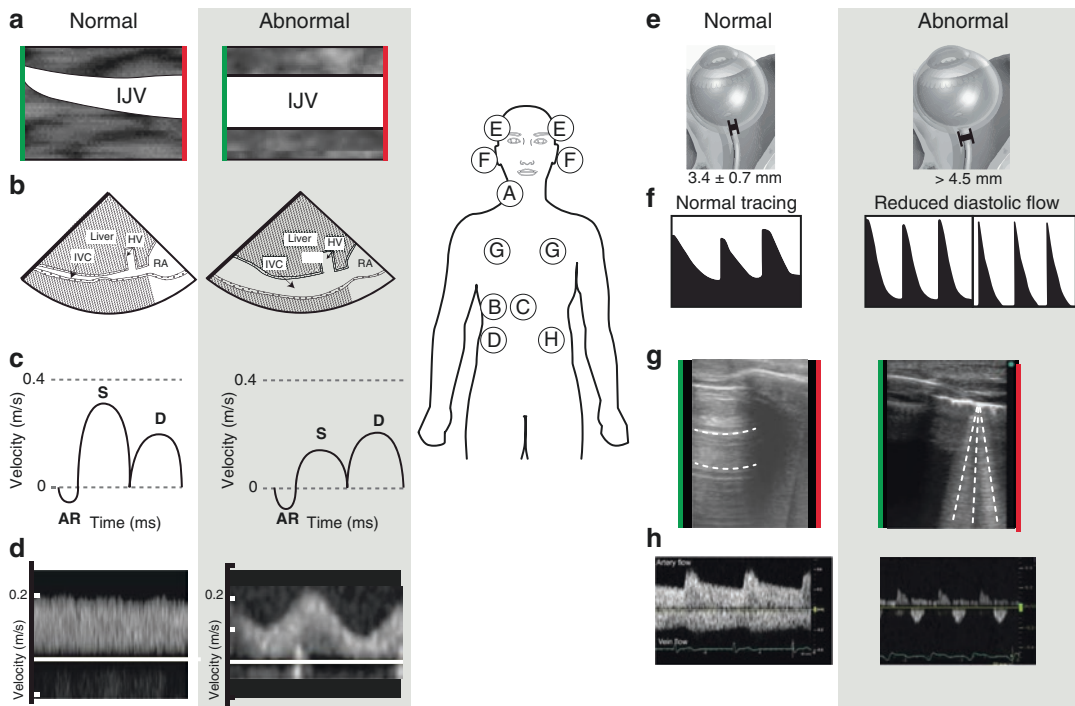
Extra-cardiac ultrasound signs of fluid overload. (a) Internal jugular vein (IJV), (b) Inferior vena cava (IVC), (c) hepatic venous flow (HVF), (d) portal venous flow, (e) optic nerve diameter, (f) trans-cranial Doppler, (g) pulmonary B-lines and (h) renal interlobar
